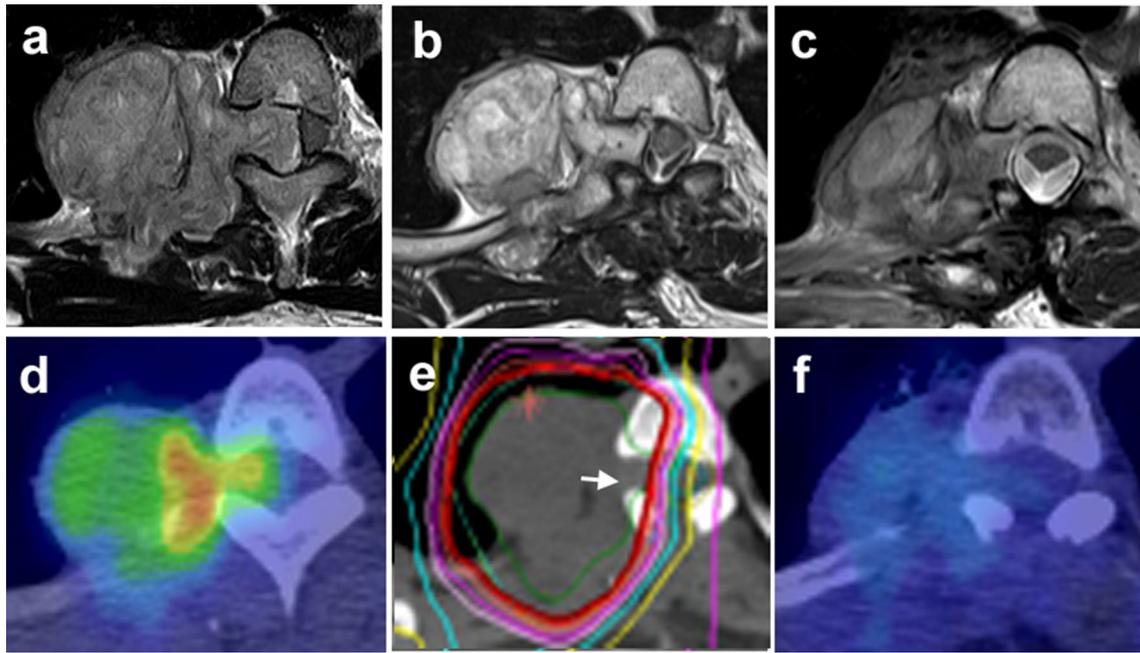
Case 3. A 34-year-old female with malignant myoepithelioma involving T3 and T4. a–c Axial T2-weighted MRI of the tumor. ESCC before surgery, after surgery, and at final follow-up was Grade 3, Grade 1b, and Grade 0, respectively. d, f Preoperative PET/CT (d)
